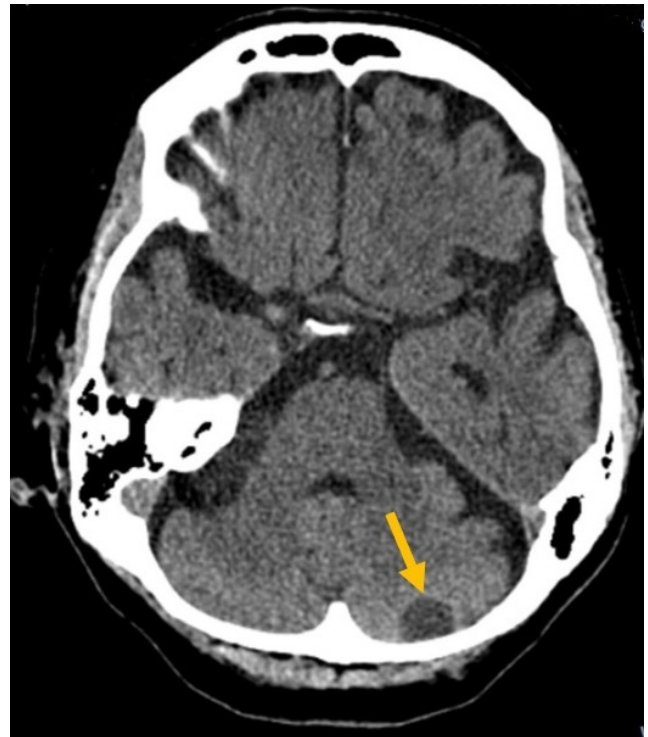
Head CT without contrast with an age-indeterminate infarct (yellow arrow) however cannot exclude underlying solid lesion.
